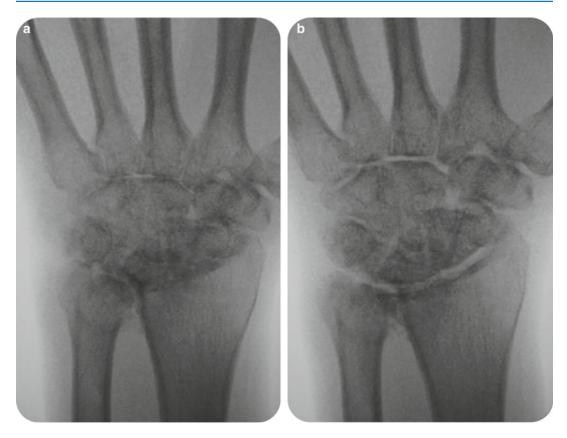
(a) X-rays are deceptive in rheumatoid wrists. There seems to have no joint space from this X-ray for the arthroscope to go into. (b) After traction is applied. The joint spaces are shown up in this traction view
